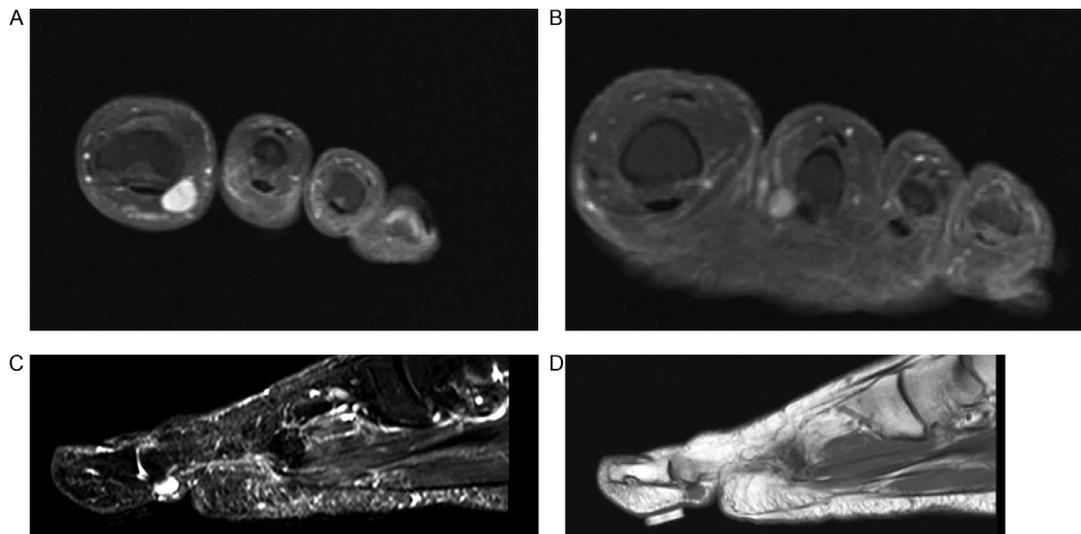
Magnetic resonance images of the soft tissue mass. (A) T2 coronal view depicting the hyperintense mass on the plantar lateral aspect of the hallux. (B) T2 coronal image showing the hyperintense mass on the plantar medial aspect of the second toe. (C) Sagittal STIR image depicting the hyperintense mass on the plantar aspect of the hallux. (D) T1 sagittal image showing the hypointense mass underlying the marker on the plantar aspect of the hallux.
